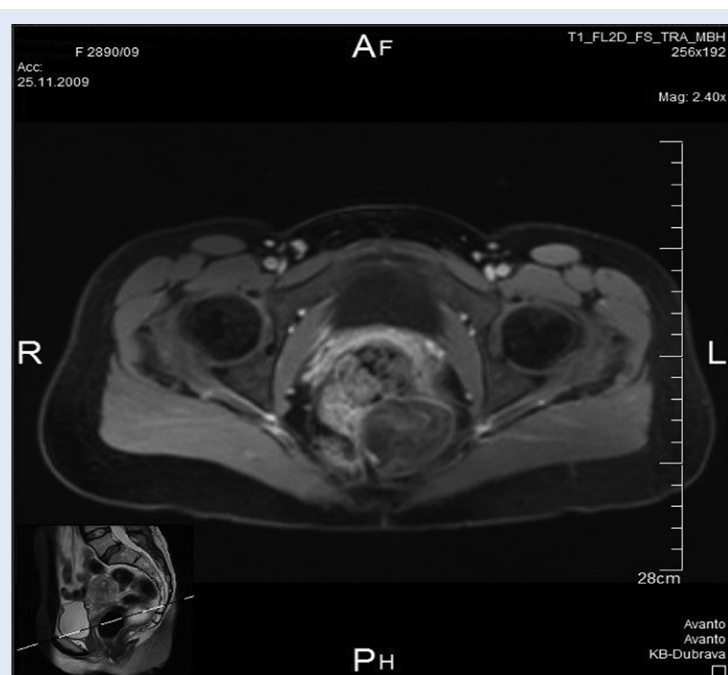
Gadolinium enhanced MRI T1W images: The lesion had only ring enhancement without enhancement inside the lesion.
